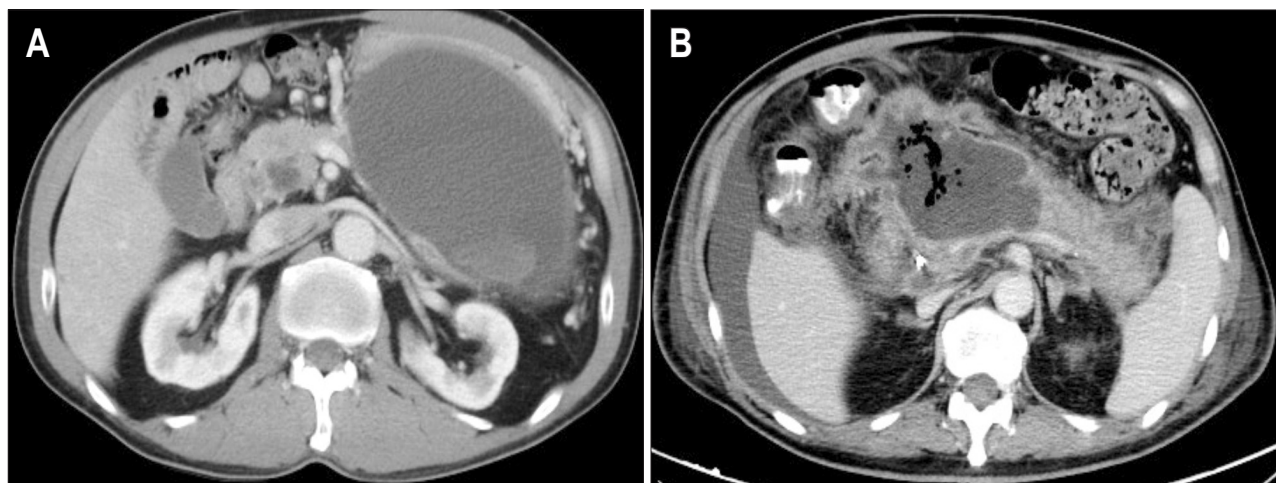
Computed tomography of (A) pancreatic pseudocyst and (B) walled-off pancreatic necrosis.
